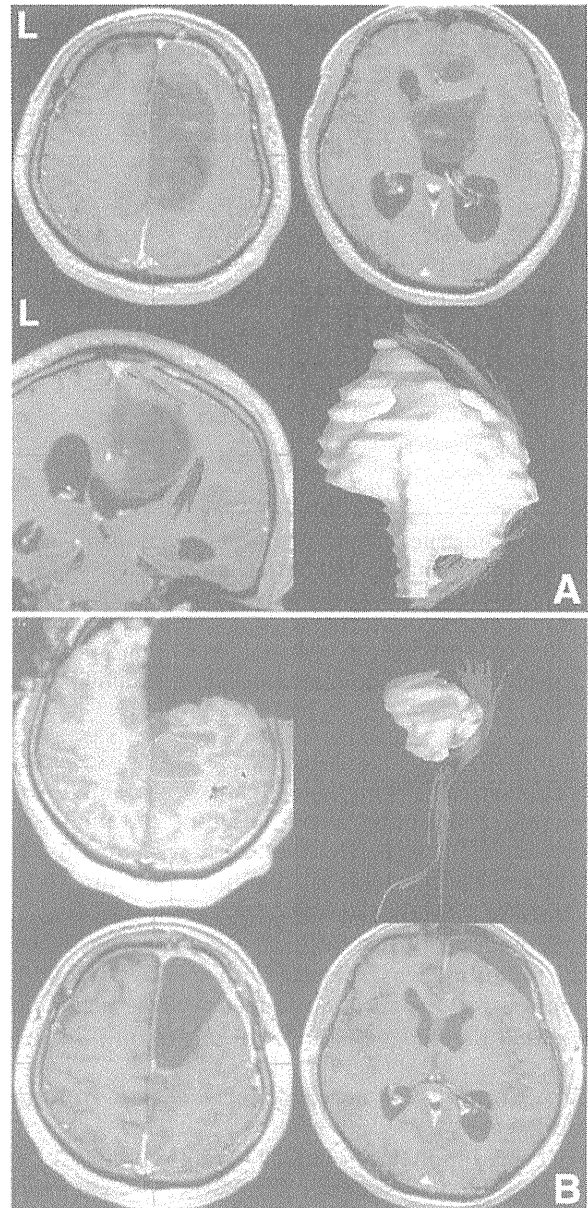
A 35-year-old male with an anaplastic astrocytoma in the right frontal lobe extending to the third ventricle. A: Preoperative magnetic resonance (MR) images (upper row) and surgical planning images (lower row) showing the pyramidal tract (rainbow) and the tumor (yellow). The pyramidal tract was shifted posterior and laterally by the tumor. B: Intraoperative MR images (upper row) revealing a tumor remnant (orange line) anterior to the pyramidal tract, resulting in resumption of resection, and total removal of the tumor (lower row). The patient developed hemiplegia postoperatively, which completely resolved after 1 week (supplementary motor area syndrome).
